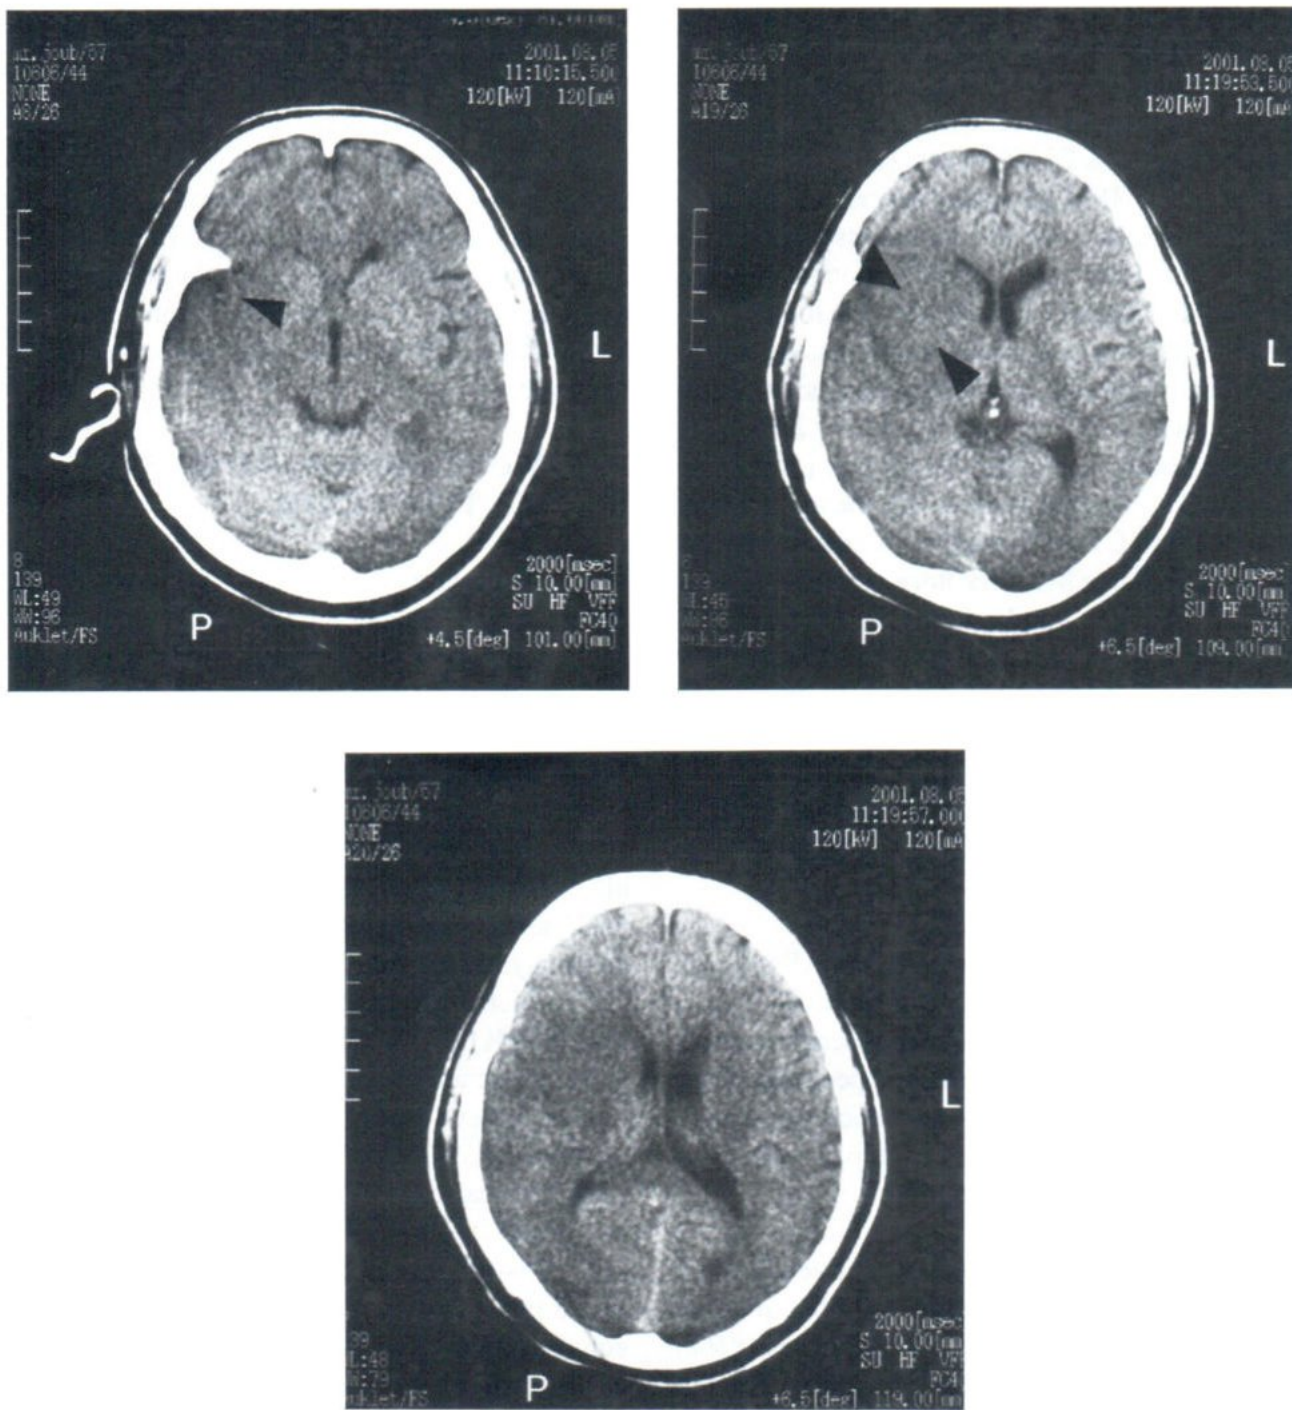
Patient presented with acute stroke about 6 hours of onset. CT scan shows loss of the insular ribbon sign (LIR) (arrow head in figure 1), Attenuation of the lentiform nucleus (ALN) sign; (between arrows heads in figure 2) and Rt. hemispheric cortical effacement (HCE) compare to normal Lt. side in figure 3.
